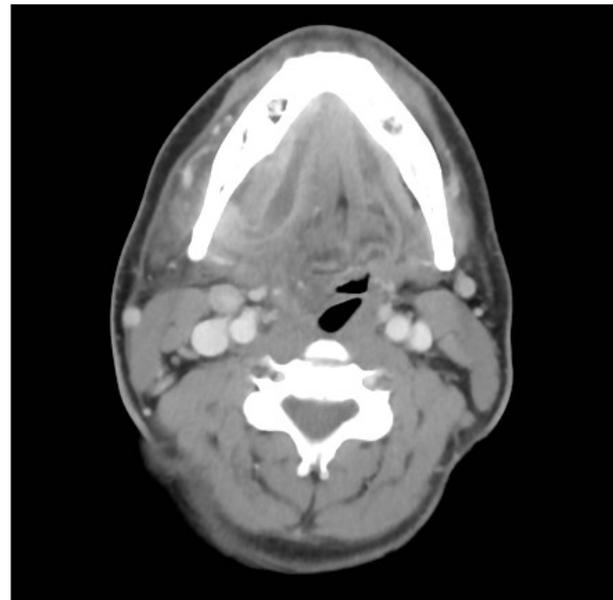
Axial CT image displaying significant reduction of the supraglottic airway due to oedema of the right lateral pharynx and base of tongue.
